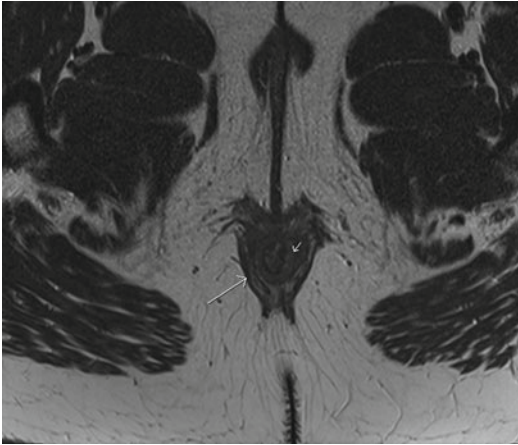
Axial T2-weighted fast spin-echo MRI image of the anus: internal anal sphincter (*small arrow*), external anal sphincter (*large arrow*) and anococcygeal ligament (*dotted arrow*)
